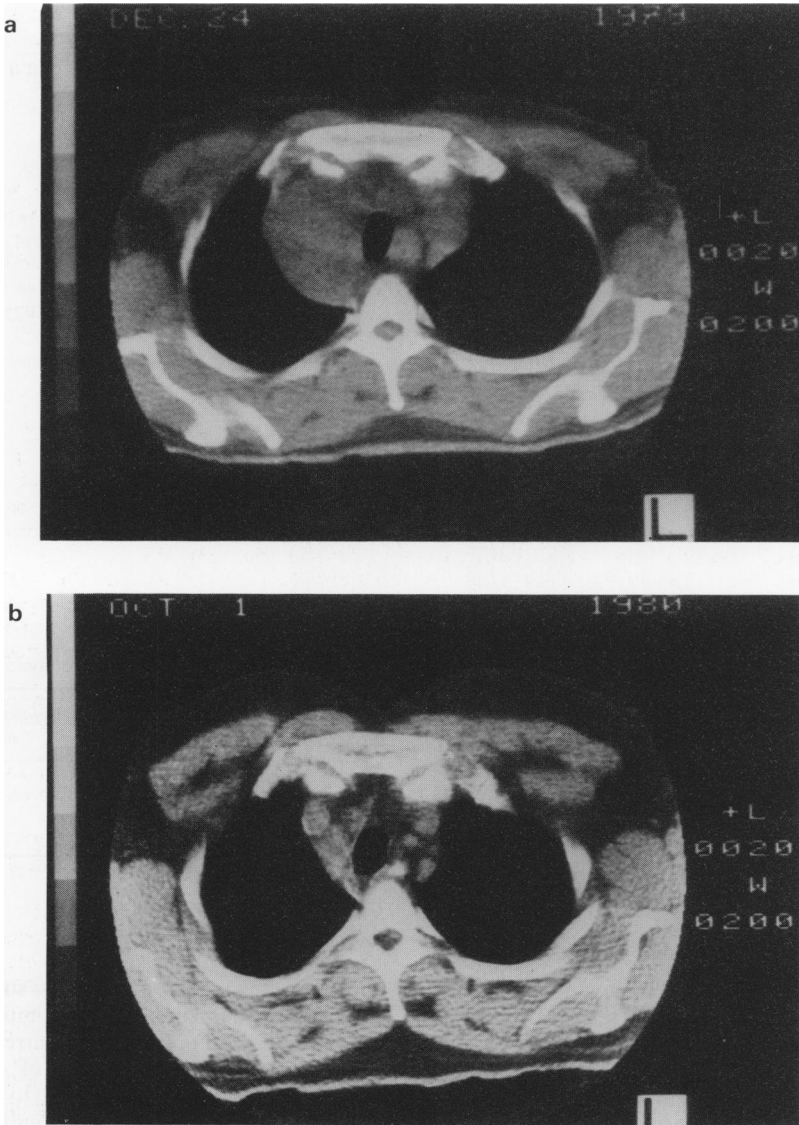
Male age 34 with HD. (a) CT scan pretreatment: mass of paratracheal nodes. (b) CT scan post treatment: residual R paratracheal mass of fibrous tissue (confirmed at thoracotomy).
